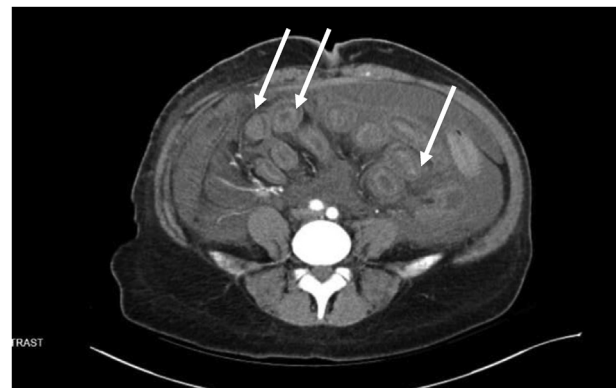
Axial view of CT abdomen showing Coomb sign.
